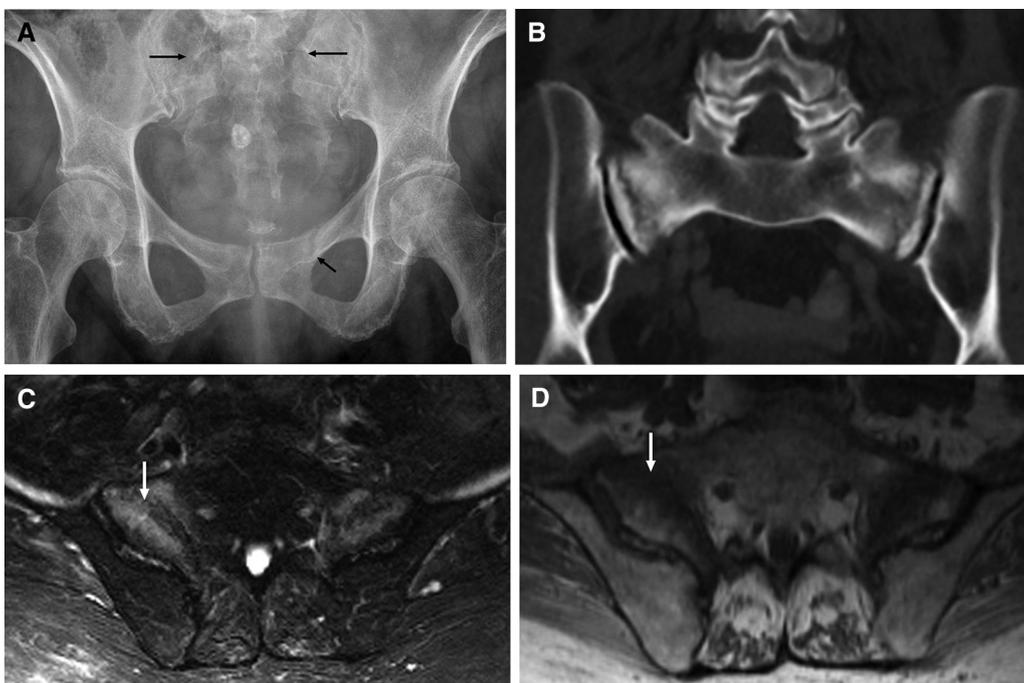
Sacral insufficiency fractures. (A) Pelvic radiograph in an elderly patient with chronic pelvic pain. Linear lucencies are noted through both sacral alae and the left superior pubic ramus, in a pattern compatible with insufficiency fractures. (B) Coronal computed tomography with bone windows confirms vertical fractures through both sacral alae. (C) Axial T2-weighted fat saturated and (D) T1-weighted magnetic resonance imaging images show T1 and T2 hypointense fracture lines (white arrows) with surrounding acute bone marrow oedema.
